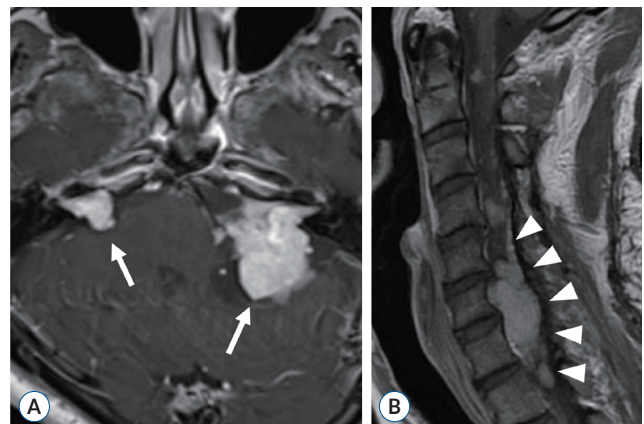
A 32-year-old male whose father, sister and brother were diagnosed with NF2 showed up with headache and pain on his neck, left arm, and right leg. Axial T1-weighted contrast-enhanced brain-MRI presented bilateral vestibular schwannomas (arrows), although the patient did not suffer for hearing loss or tinnitus until the age of 50 years (A). However, the pains were caused by an intradural-extramedullary tumor (non-vestibular schwannoma) in the cervical canal at level C4-6 (arrowheads), shown in a sagittal T1-weighted cervical spine MRI (B). NF2 : neurofibromatosis type 2, MRI : magnetic resonance imaging.
